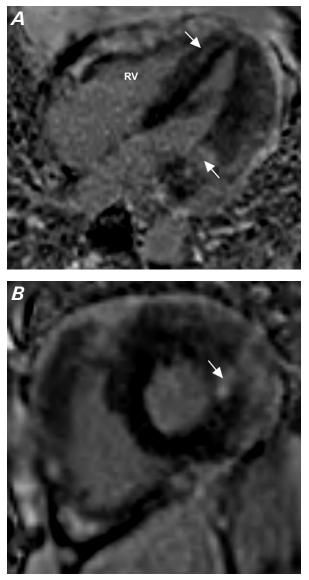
Cardiac magnetic resonance images with late gadolinium enhancement show diffuse, patchy, mostly midmyocardial uptake throughout both ventricles, most prominently in the lateral walls. A) The 4-chamber view shows enhancement along the basal lateral left ventricular septum (arrows), and B) the short-axis view shows uptake in the lateral mid myocardium.
